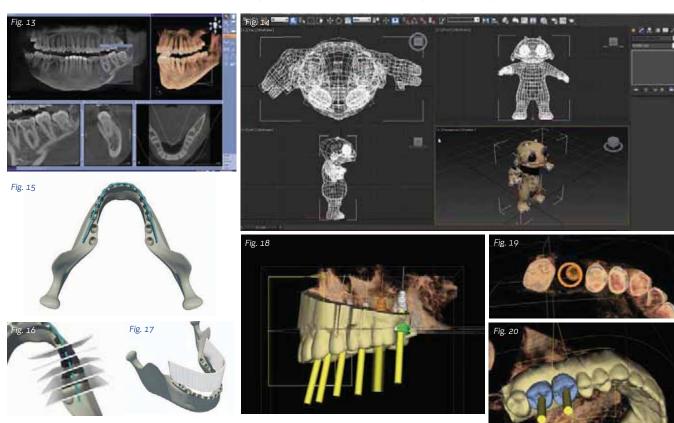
Screen arrangement of a guided surgery/CBCT viewer.
